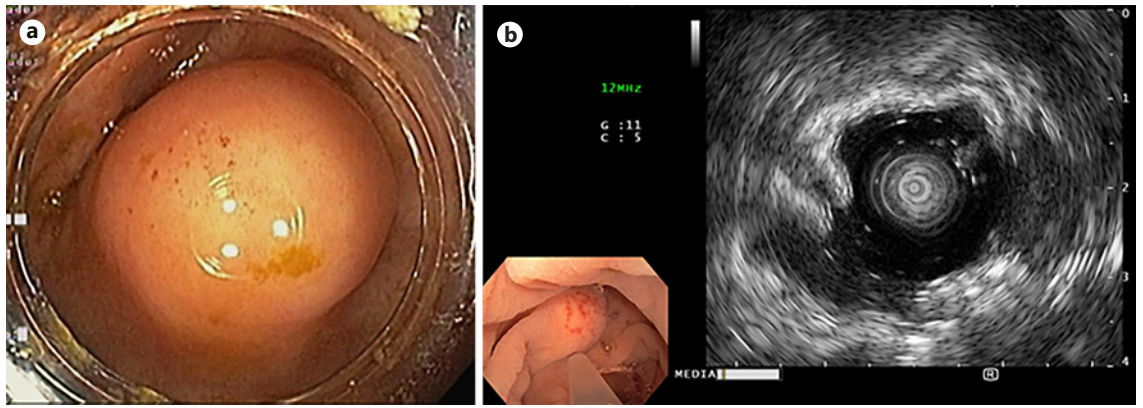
Endoscopic findings. a In the cecum, a 15 mm bulge with normal mucosa was observed. b Ultrasonography – a subepithelial nodular lesion was confirmed, although it was not possible to safely distinguish between the second and third ultrasonographic wall layers.
